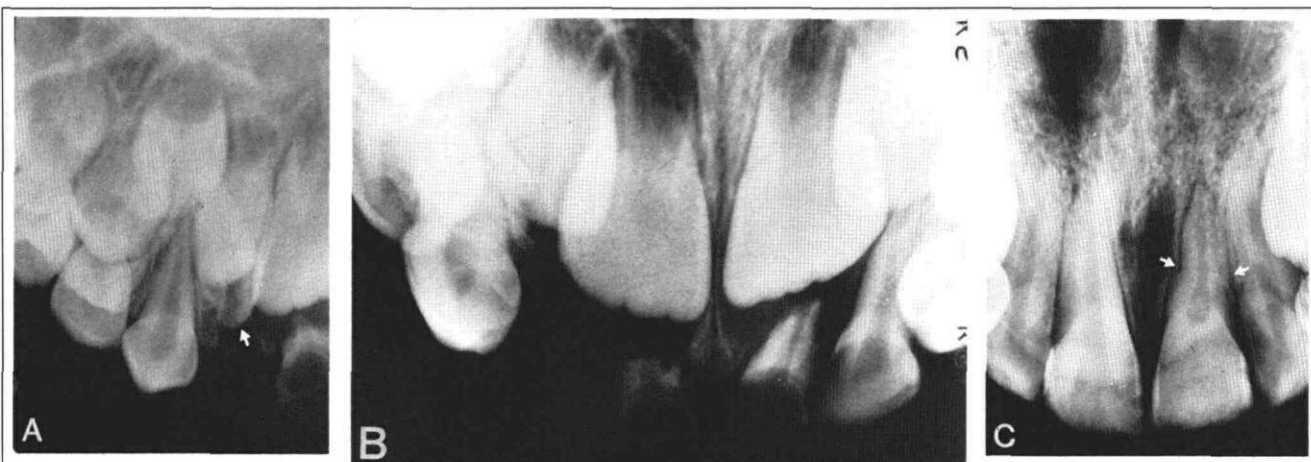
Patient 39. A & B. Periapical radiographs taken 2 days after the trauma. Note the intruded B| and the pathologic root resorption of A|A accompanied by periapical bone destruction. C. Periapical radiograph taken at age 10 years. Note the dilaceration at the middle one-third of the root of 1| and an obliteration of its pulp chamber.
